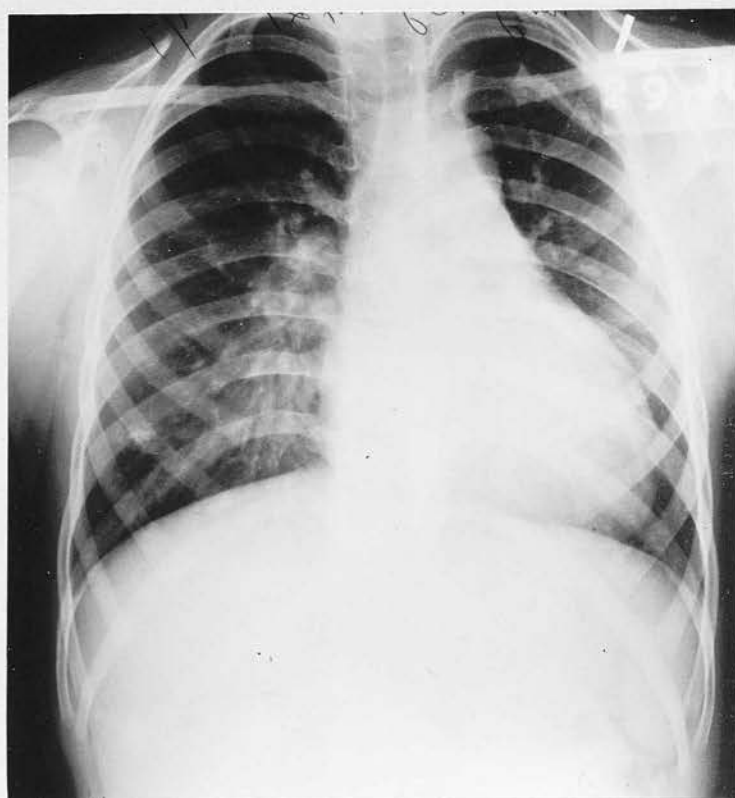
Radiograph of Case 36. Reduction in cardiac size and marked reduction in pulmonary vascularity following ligation of Patent Ductus at 5yrs.
